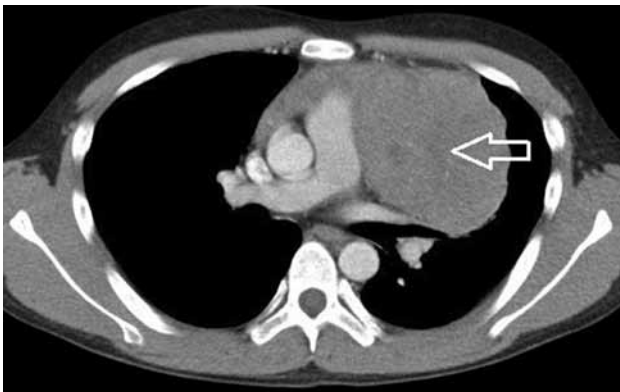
Thoracic contrast-enhanced computed tomography showing a mass of soft tissue density in the anterior mediastinum (white arrow).
